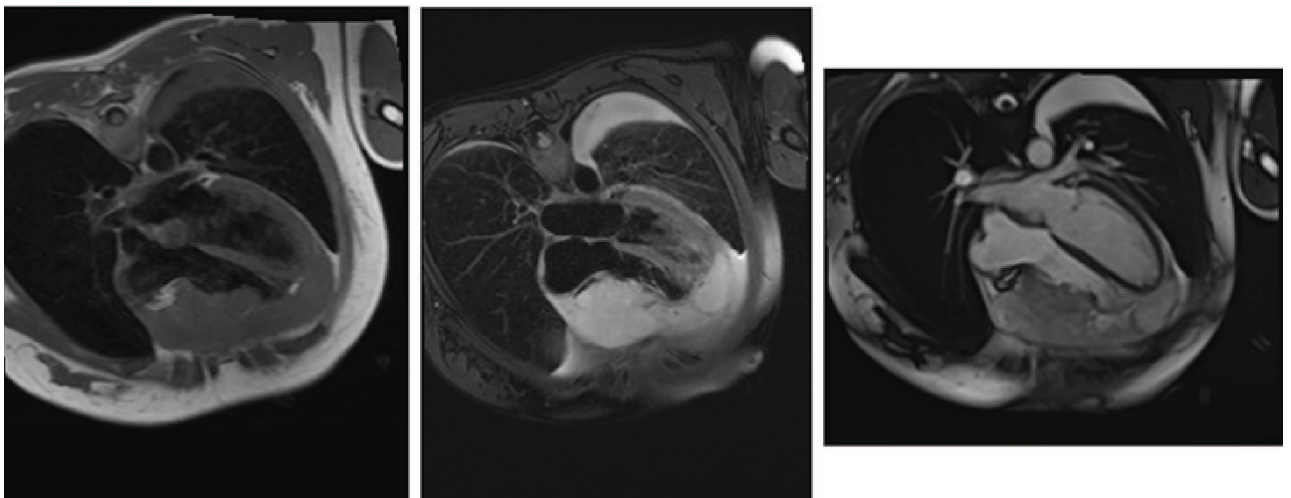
Magnetic resonance imaging of the tumor.
